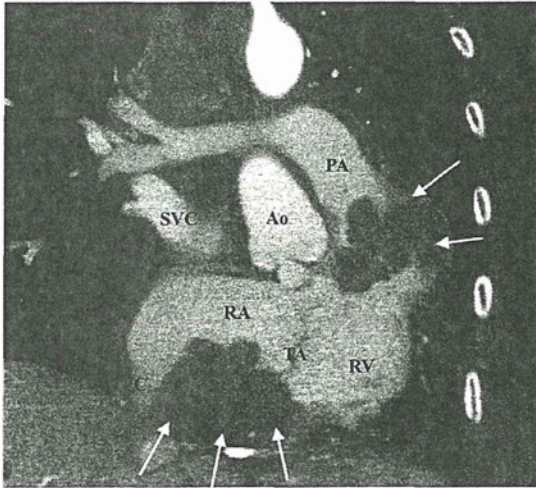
Contrast computed tomographic image shows the cardiac tumor (white arrows) protruding into the right atrium (RA) and right ventricle (RV), and causing an RV outflow tract obstruction. Ao, aorta; PA, pulmonary artery; TA, tricuspid valve annulus; SVC, superior vena cava; IVC, inferior vena cava.
